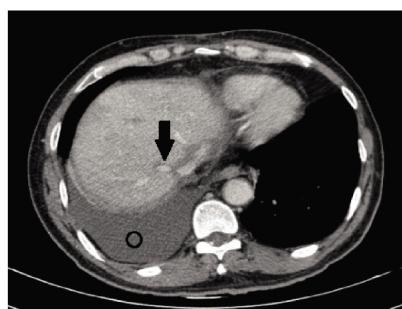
44岁男性,因重症肝炎行原位肝移植手术,术后肝功能异常,肝穿刺示中度急性排斥反应,术后 560 天 CT 示肝静脉周围 PVLs(黑色箭号),右侧胸腔积液(黑色圆圈)。
